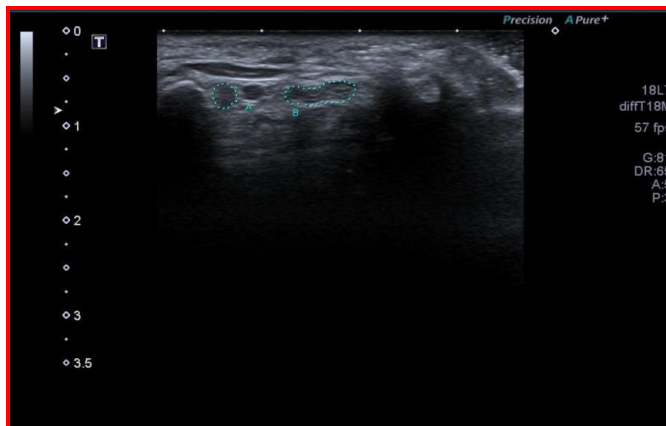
A picture taken of the ulnar and median nerves near the pisiform bone using ultrasound technology. Median nerve (B) and ulnar nerve (A).
